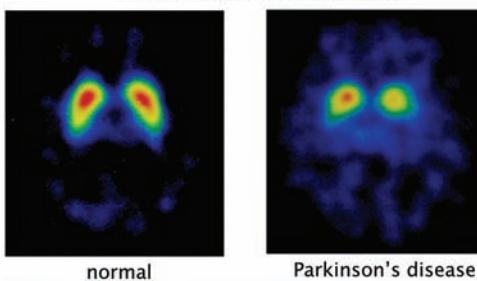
^{123}I - β -CIT SPECT images in normal subject (left) and in a patient with Parkinson's disease (right). Reduction of ^{123}I - β -CIT indicated a failure of dopaminergic signal transduction from substantia nigra to putamen in Parkinson's disease (right).
